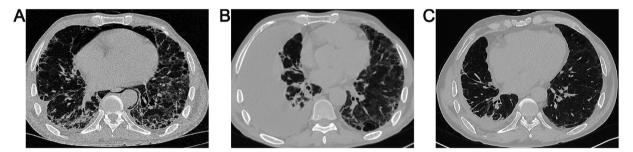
Changes in HRCT findings of Case 1. A, Before DNA immunoadsorption, reticulation and consolidation could be seen. B: two months later after DNA immunoadsorption, faded reticulation while increased pleural effusion in the left lung could be found; C: two years later after DNA immunoadsorption, reticulation and consolidation evaporated virtually and gradually reduced pleural effusion in the left lung could be found.
